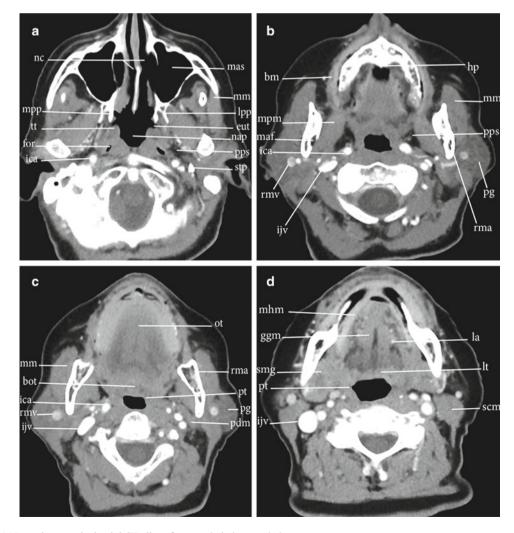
(a-h) Normal anatomical axial CT slices from cephalad to caudad
